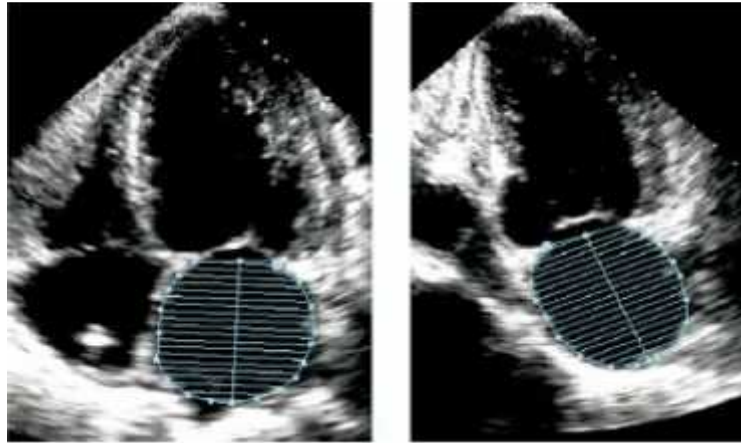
Measurement of left atrial (LA) volume from biplane method of disks (modified Simpson's rule) using apical 4-chamber (A4C) and apical 2-chamber (A2C) views at ventricular end systole (maximum LA size).
